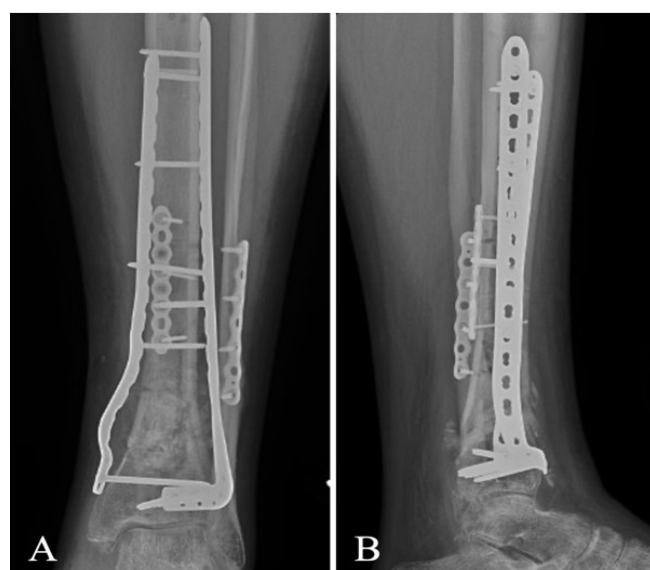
Six weeks post-revision radiographs of the left ankle including (A) anteroposterior and (B) lateral views demonstrating well-maintained tibial alignment with intact hardware. Autogenous bone graft placed during the revision surgery appears to be maturing. There is some increased bony callus formation over the lateral aspect of the tibia.
